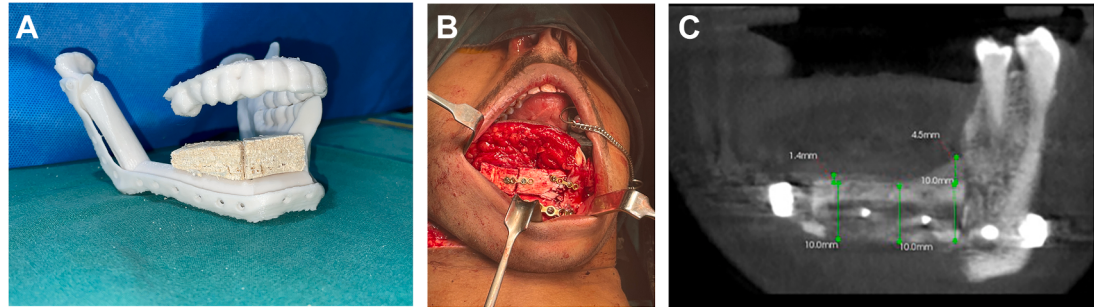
(A–C) NANOTEX. (A) Bone Substitute Nanotex used for augmenting bone height. (B) Intraoperative picture demonstrating the use and how to fix the NANOTEX. (C) Postoperative radiograph demonstrating the increase in height achieved by the use of NANOTEX.¹¹
